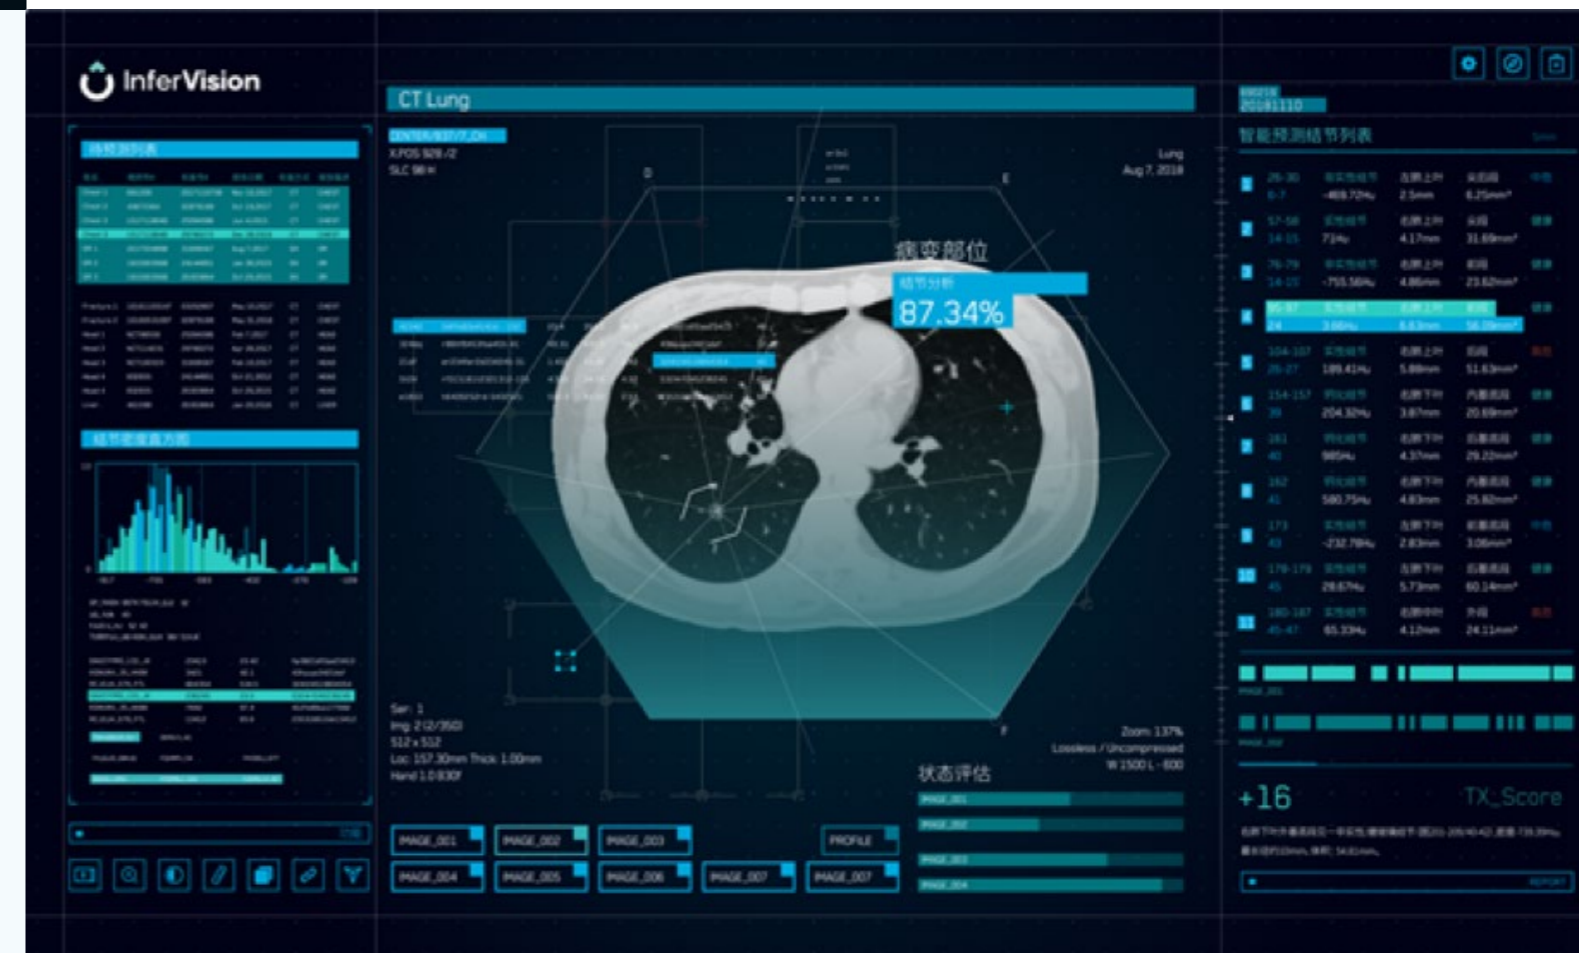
InferVision's InferRead Lung CT.AI
